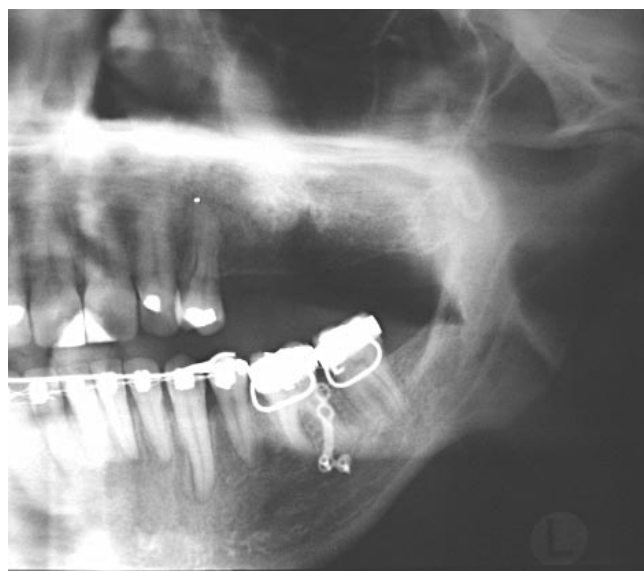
Postintrusion panoramic radiograph of patient 2.
